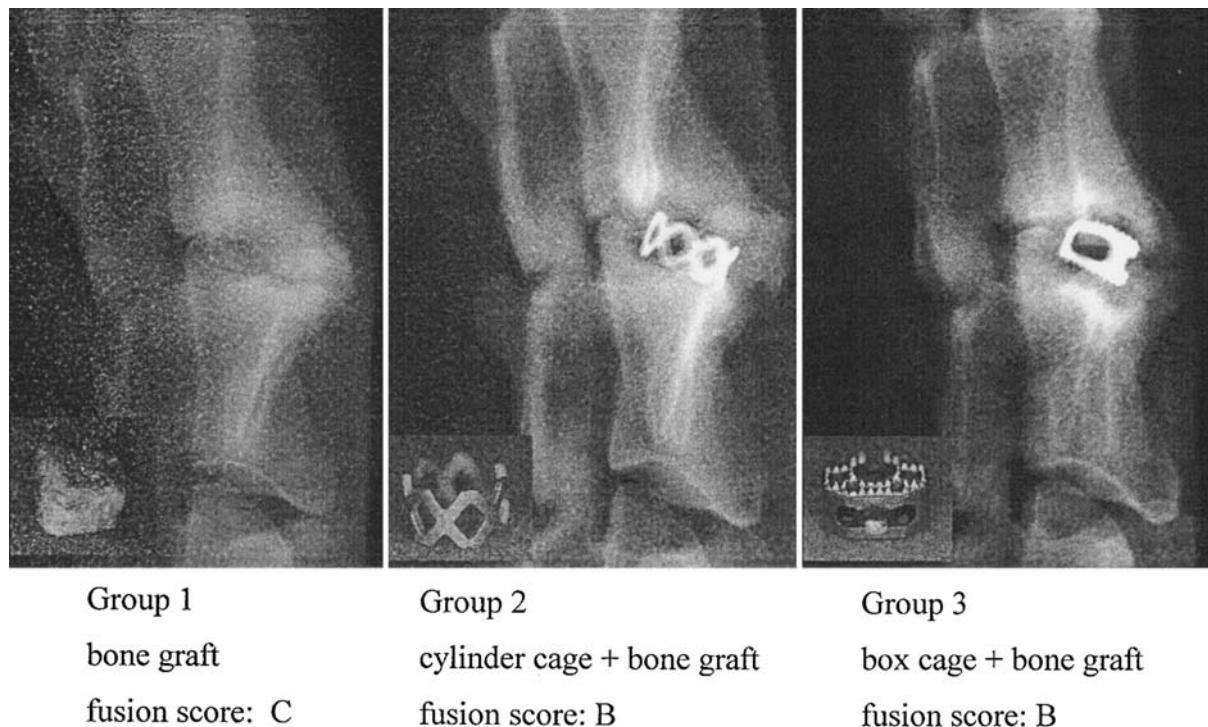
Radiographic analysis. After 12 weeks, the extent of osseous fusion was evaluated on radiographs. The small pictures within the radiographs show the different implants. Notice the larger contiguous cranial pore in the cylinder-design cage. The results of the fusion score are depicted: A, no osseous fusion; B, maximum intervertebral gap of more than 5 mm; C, maximum intervertebral gap of less than 5 mm; and D, complete osseous fusion.
